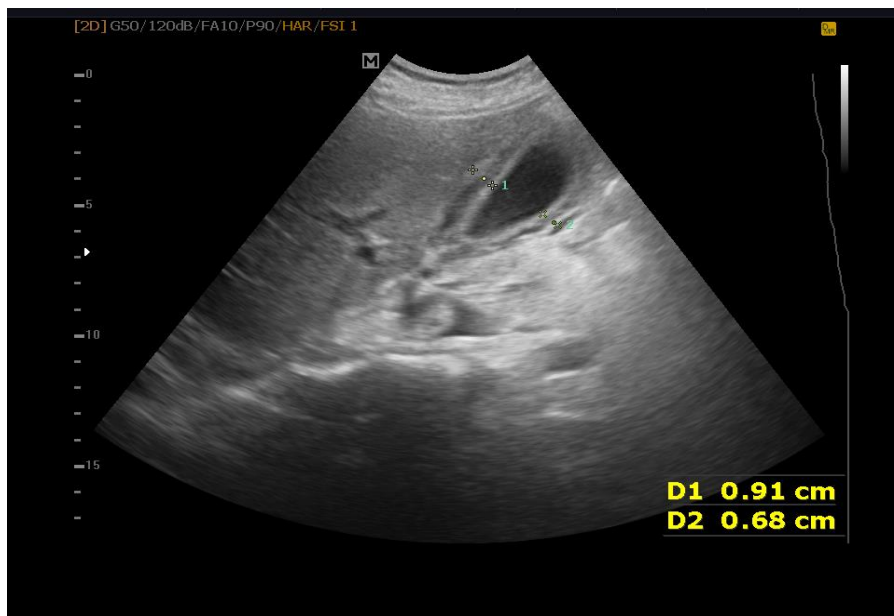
The ultrasound image of a patient with acute hepatitis(AST- 890 , ALT - 567) showing thickened wall of gall bladder (the anterior gall bladder measures 9.1 mm and Posterior wall measures 6.8mm)
